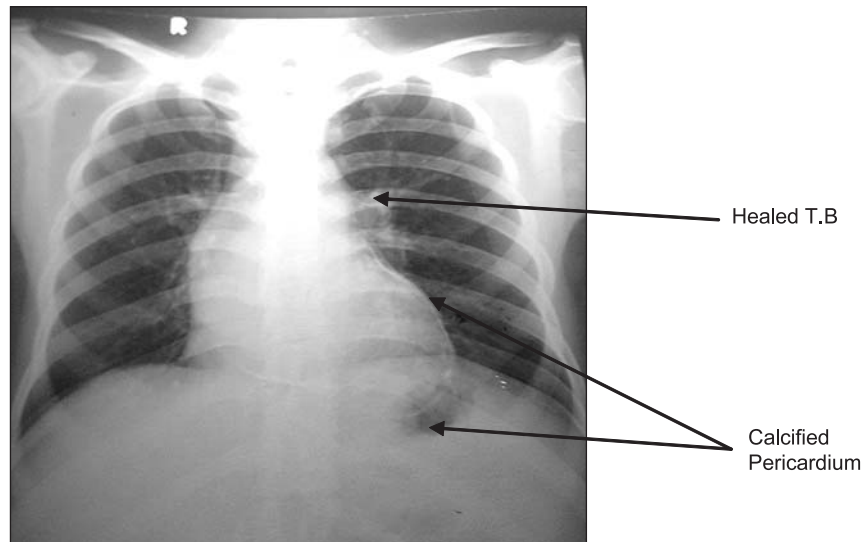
X-ray chest shows calcification of pericardium on the surface of left ventricle and healed T.B on left lung near to the hilar region.
